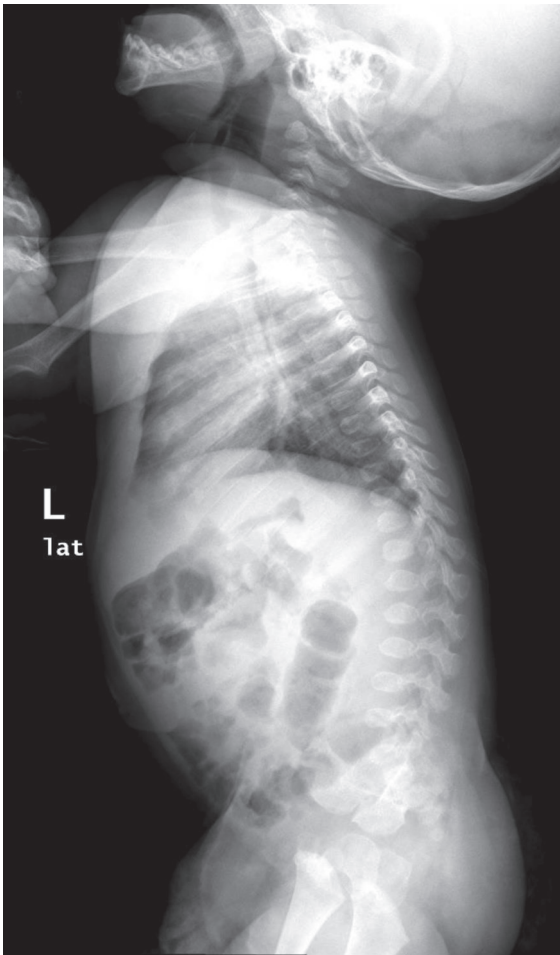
Lateral dorsolumbar radiograph shows oval vertebral bodies with an anterior inferior beak.
